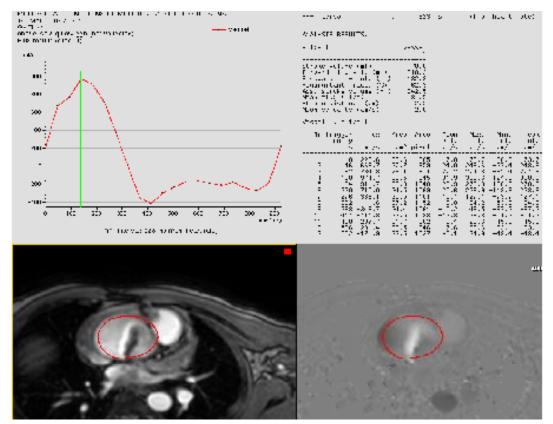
MRI quantitative flow assessment in a patient with a bicuspid aortic valve and ascending aortic dilatation (circled region of interest in the bottom frames). The top left frame is a graphic representation of flow across the region of interest at the level of the aortic valve. The top right frame demonstrates volumes and flow velocities in tabular form. This patient was shown to have increased velocities and severe aortic regurgitation. He underwent successful replacement of his aortic root and aortic valve
